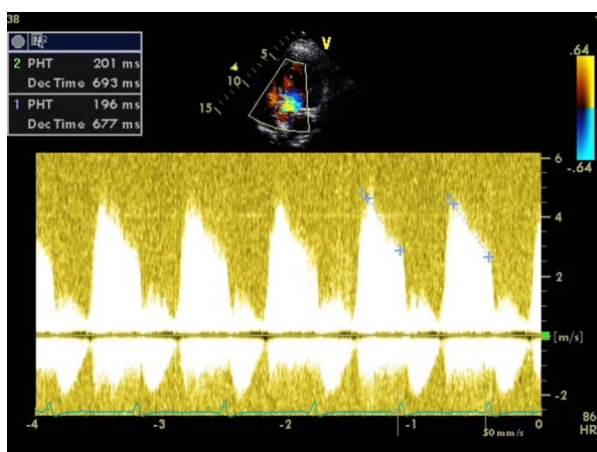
Echocardiographic image, continuous-wave Doppler at left ventricular outflow tract showing aortic regurgitation pressure half time of 200 ms.
